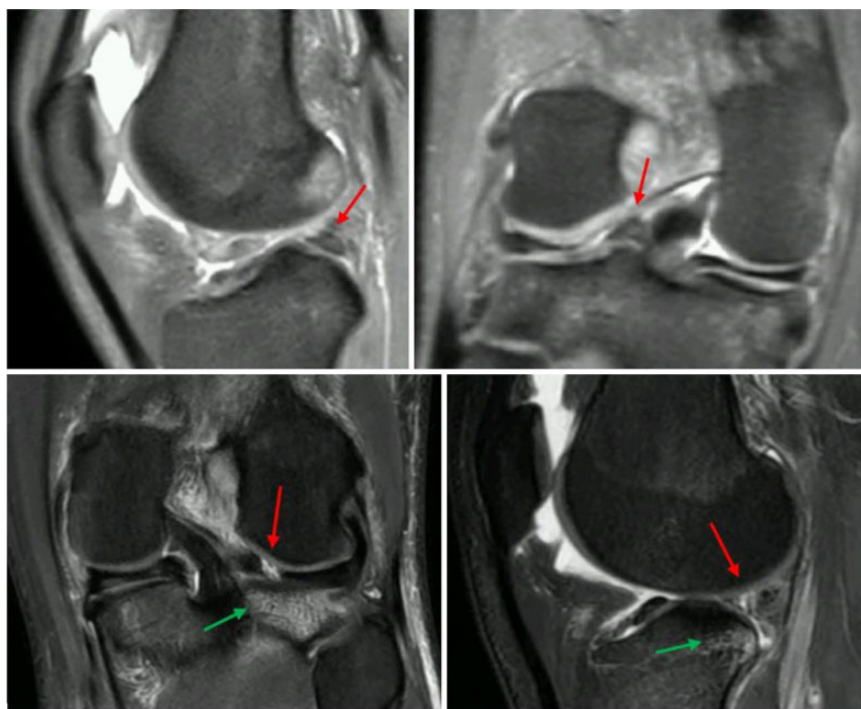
Ghost signs (red arrows) and hyperintensity under the articular surface across the meniscus root (green arrows) on right and left knees MRI scans.
